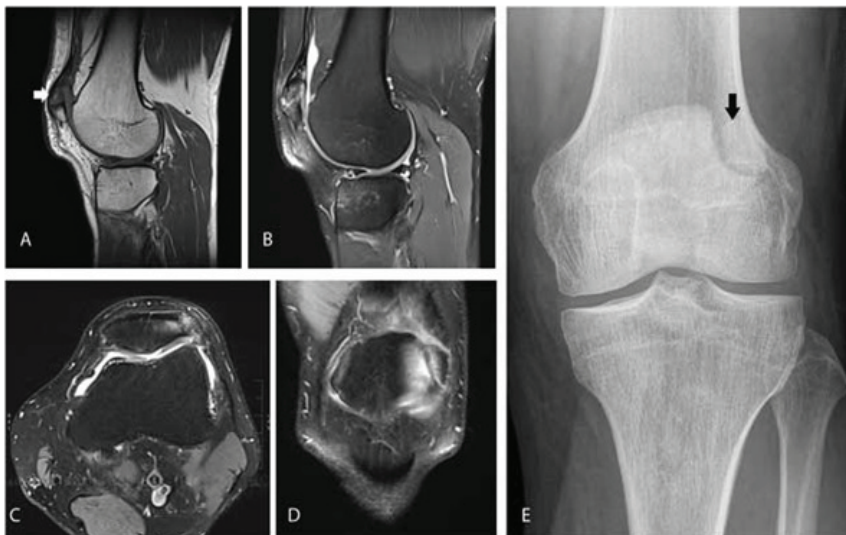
Symptomatic bipartite patella in a patient with anterior knee pain. Although bipartite patella can be an anatomical variant, it can also be a source of pain similar to a pseudarthrosis. Sagittal T1-WI (A) shows a separate bone fragment at the superolateral aspect of the patella (arrow). Sagittal (B), axial (C) and coronal (D) FS T2-WI reveal bone marrow oedema within the accessory fragment and the adjacent superolateral aspect of the patella. Plain radiography (E) confirms a sclerotic delineated accessory fragment at the superolateral aspect of the patella however the oedema indicative of active inflammation is radiographically occult.
